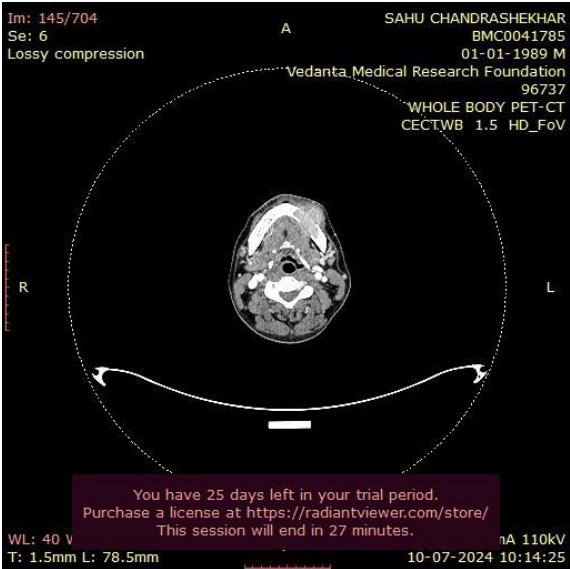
Radiographic photographs
